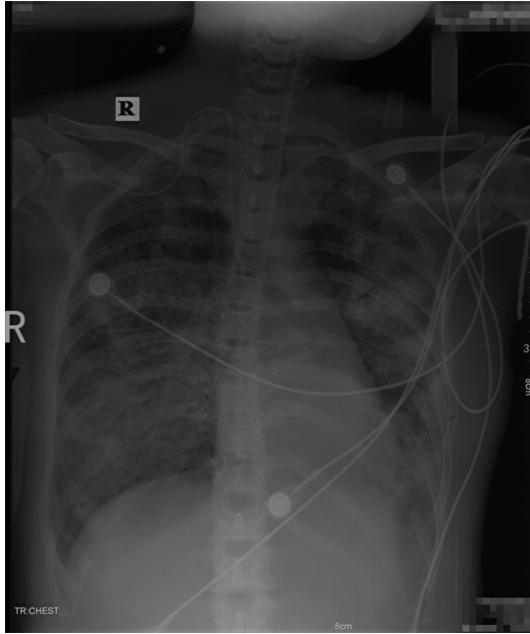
Chest X-ray showed an exudative change of lungs.
